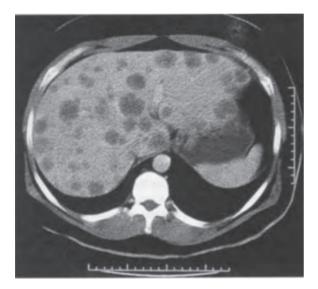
CT scan showing multiple hepatic metastases.
